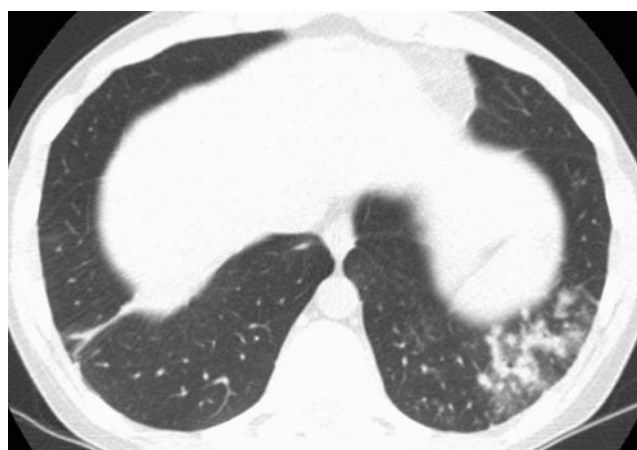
A 31-year-old, female, lung transplant recipient with novel influenza A (H1N1). High-resolution CT scan demonstrates focal soft tissue centrilobular nodules progressing to lobular consolidation within the left lower lobe. While these findings are associated with the distal airways, this finding is more commonly seen with bacterial bronchopneumonia
